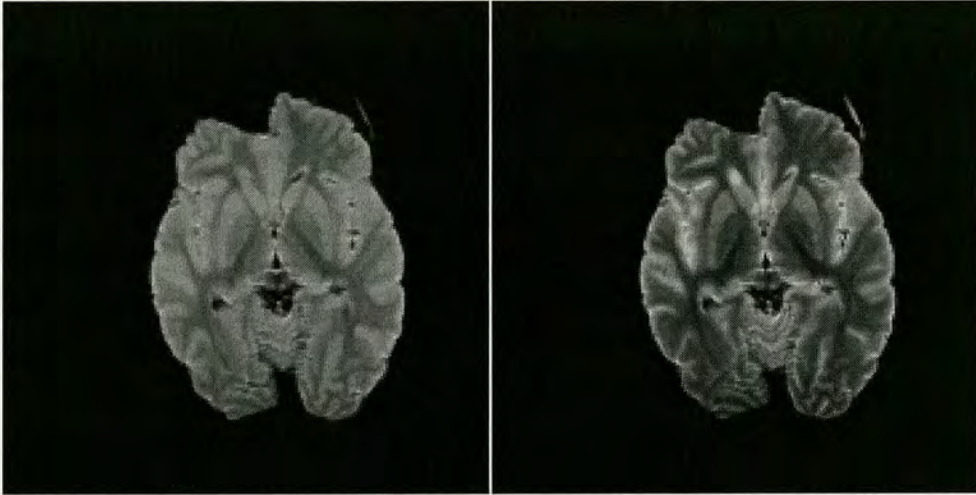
A typical PD weighted MRI (left) and a typical T2 weighted MRI (right) of the same brain region in each case.*
